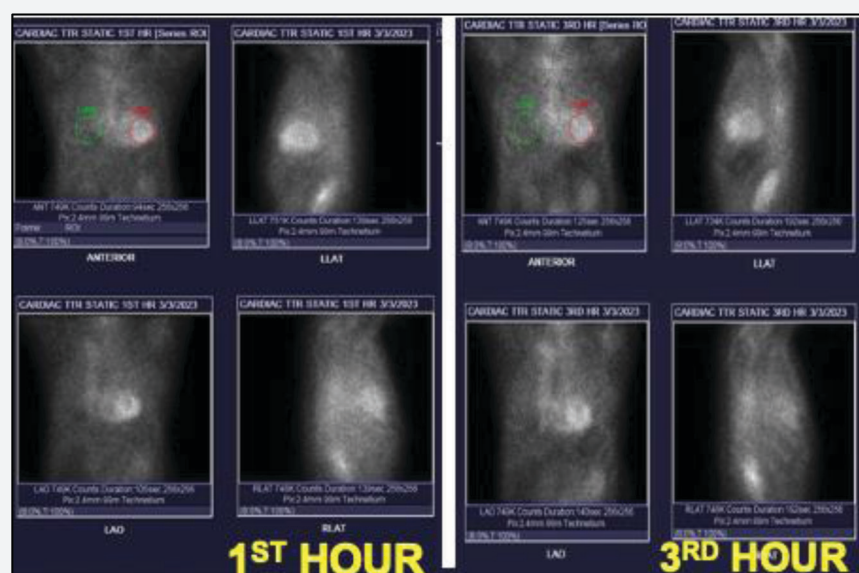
SPECT images showing diffuse myocardial tracer uptake. The calculated heart/contralateral chest ratio (HCR) was 1.7 on both the 1st and 3rd hour scan which strongly suggest TTR cardiac amyloidosis
